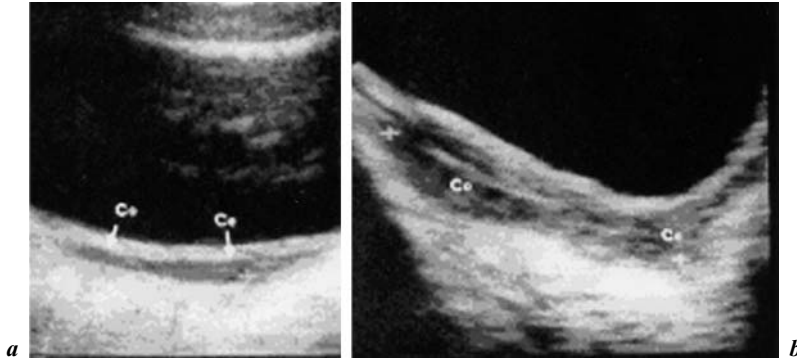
Ultrasound aspect of uterus before puberty (a) and after puberty onset (b) [from 1].
